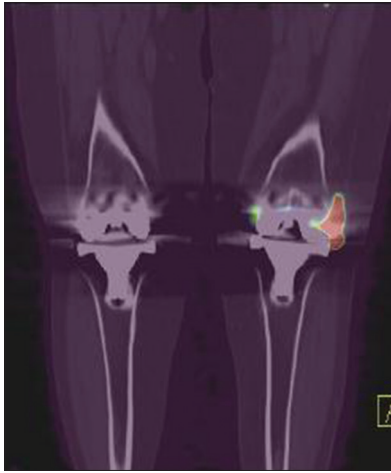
Coronal fused positron emission tomography-computed tomography also showing increased uptake in left knee prosthesis region correlating with methylene diphosphonate and ubiquicidin
